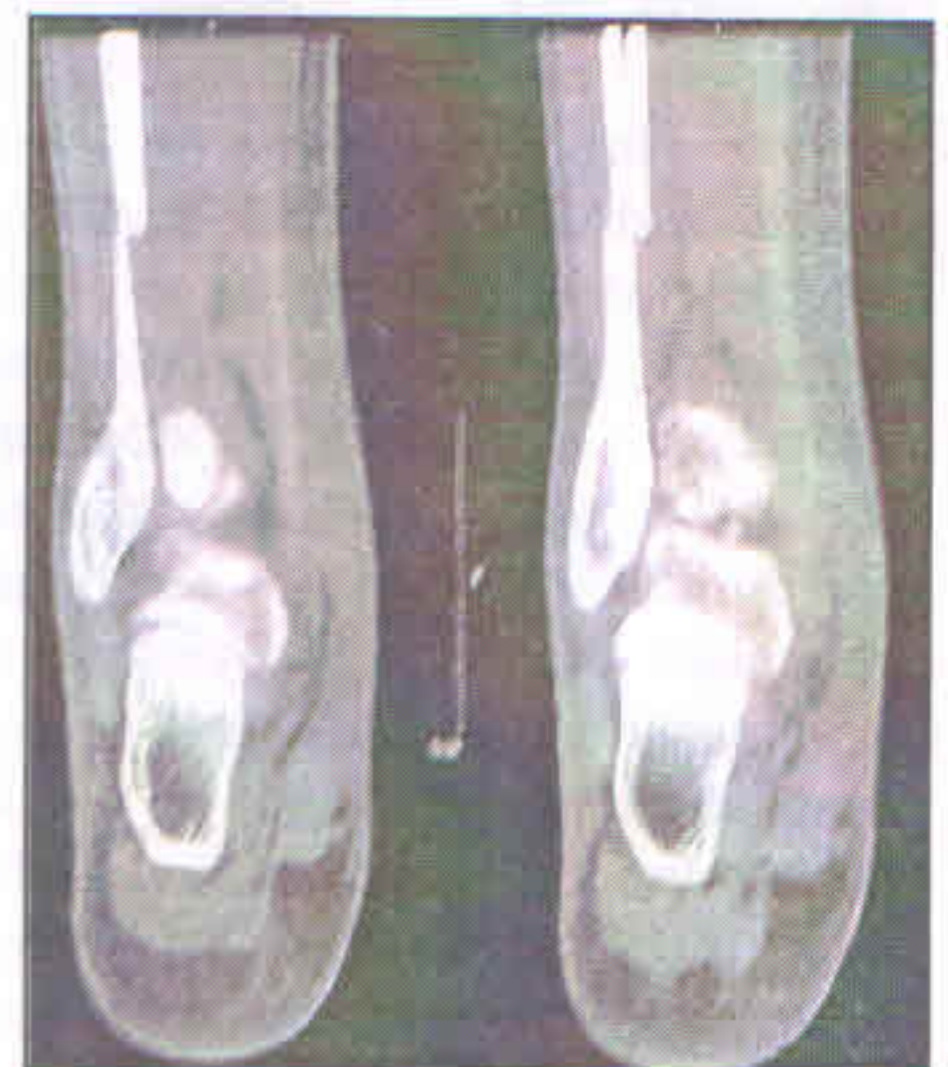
CT coronal view of the same patient. A CT scan may at times not give any indication of instability.
